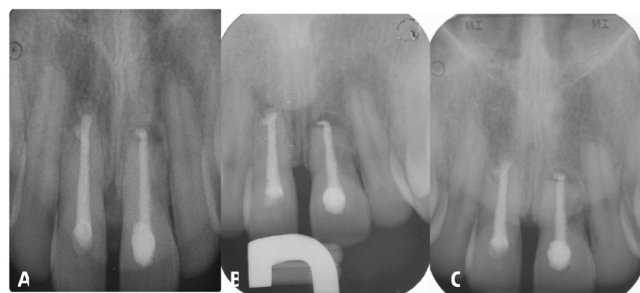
Radiographs at 6 months after the apicoectomy of tooth #11 and at 18 months after the trauma (A), at 24 months after the trauma (B) and at 30 months after the trauma (C). Apicoectomy allowed the drastic decontamination of the periapical canal system and stopped the root resorption phenomenon
